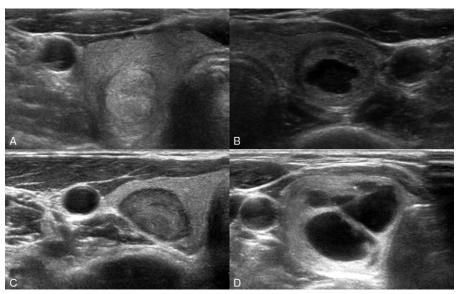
Transverse ultrasound image of macrofollicular variant of PTC, which has well-defined smooth margin, ovoid to round shape (A–D), and which shows isoechogenic solid nodule (A) or hypoechogenic nodule (C), or mixed echogenic nodule (B, D). (A—patient 2; B—patient 3; C—patient 6; D—patient 9). PTC= papillary thyroid carcinoma.
